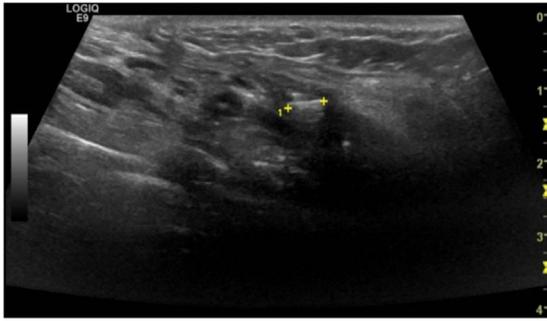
Ultrasound of the neck showing the presence of a foreign body.
